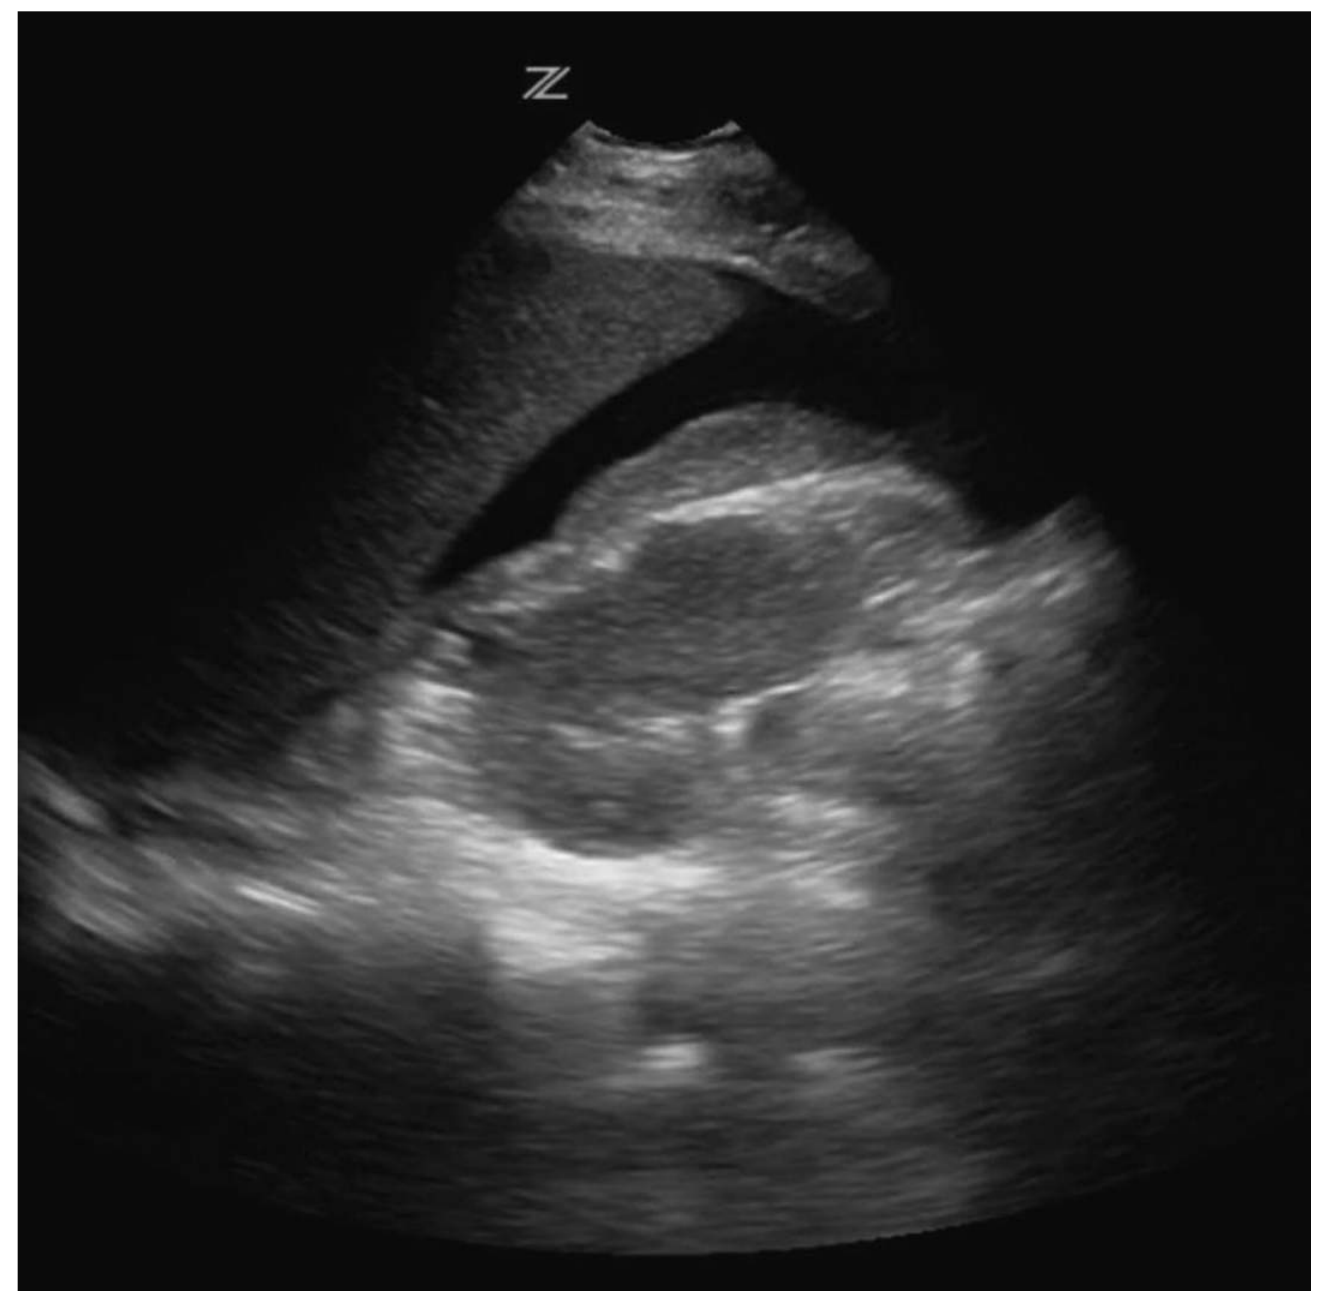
■ Positive FAST Examination. This anechoic (dark) fluid in Morrison pouch represented blood in this patient. As with nonabusive trauma, ultrasound is a rapid, noninvasive way to screen for abdominal injury in an unstable patient, but is not sufficiently sensitive to detect smaller abdominal injuries that may, nevertheless, have important forensic significance. (Photo contributor: Jason W. Fischer, MD, MSc.)
